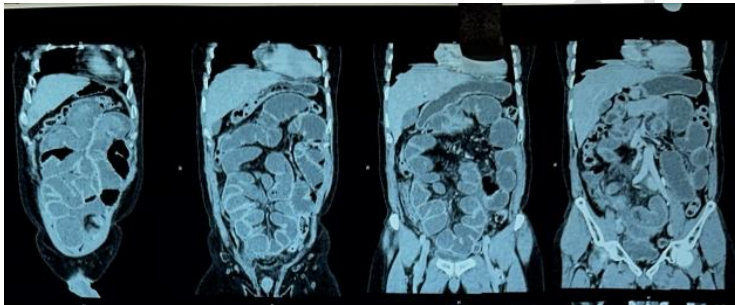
showing coronal section of CT abdomen and pelvis showing clumping of bowel loops in the Centre of the abdomen with matting of bowel loops. Loops are embedded in a thin walled sac with localized fluid collection mostly duodenojejunal flexure and proximal part of jejunum were embedded in the sac
